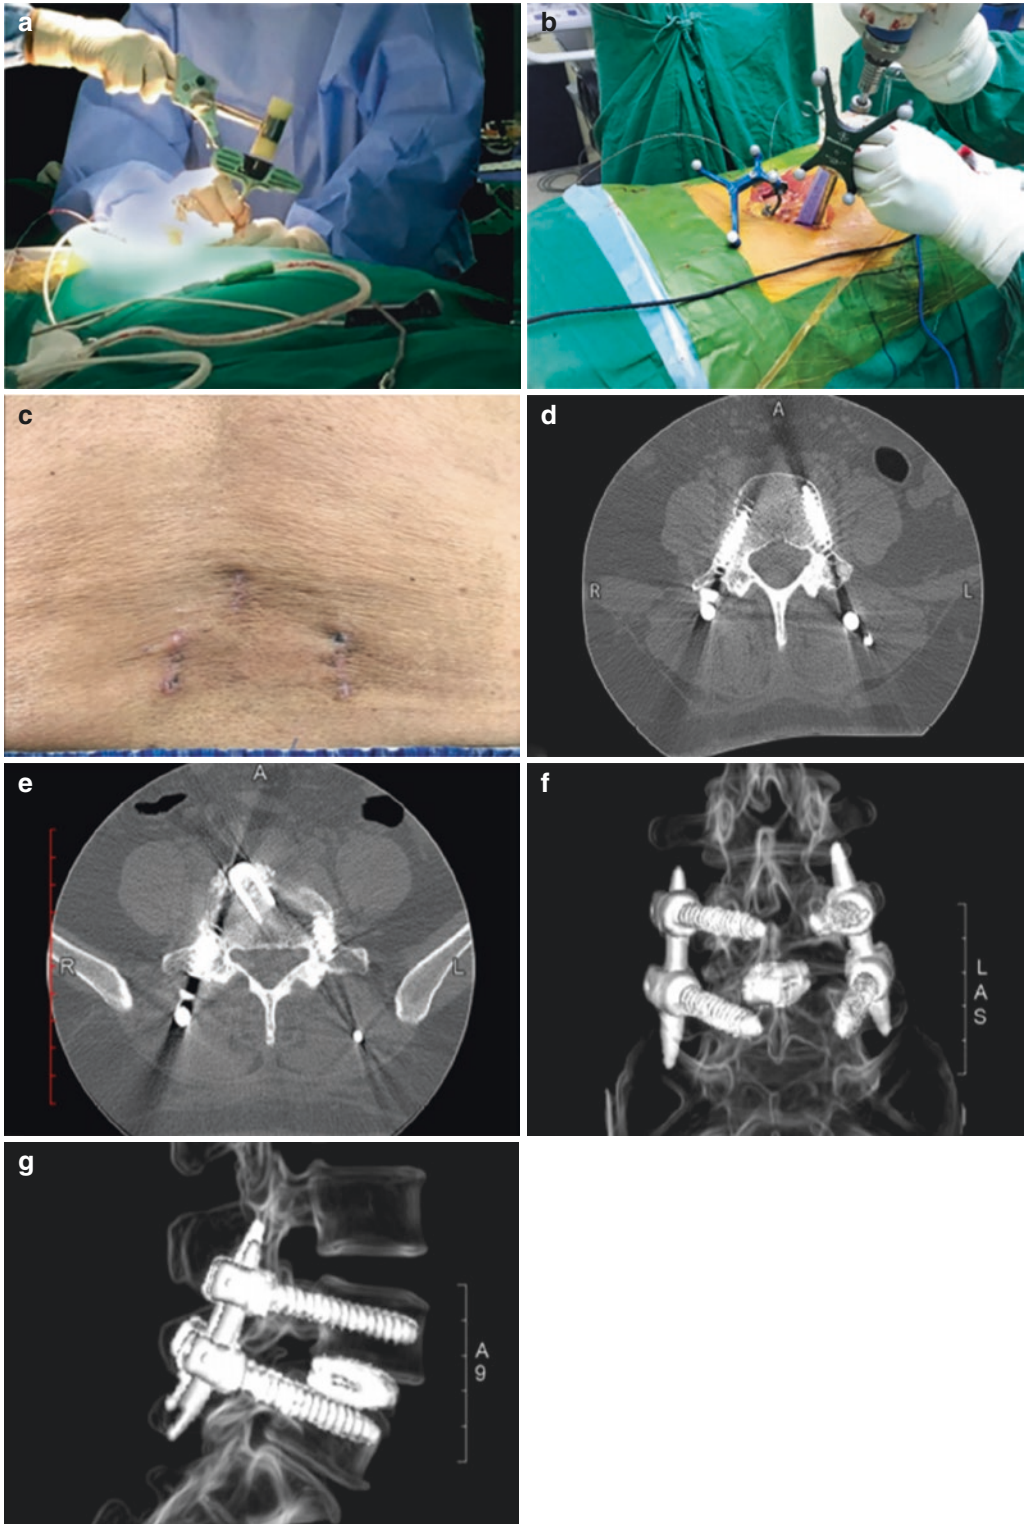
(a, b) Set-up of navigation apparatus (b, c) Healed scar area; (d–g) CT scan showing good alignment of pedicle screws with interbody cage
